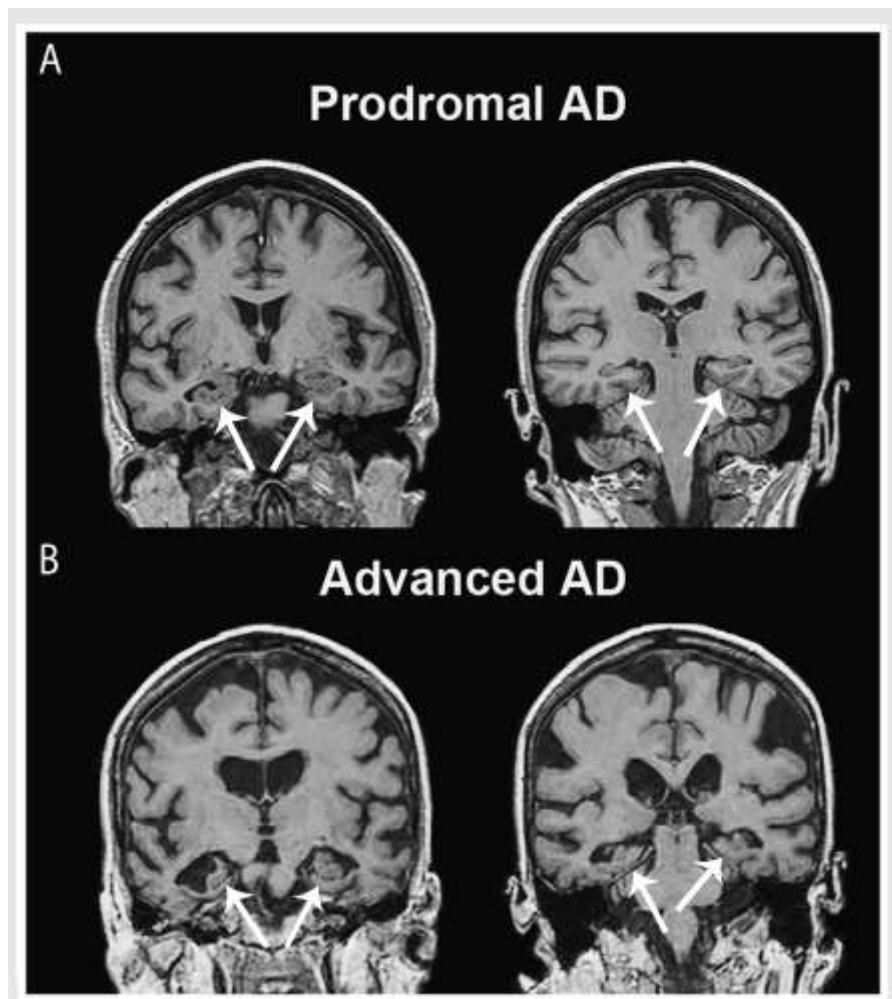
Coronal T1-weighted MRI slices with findings suggestive of Alzheimer disease (AD) pathology show mesial temporal atrophy (A, B, arrows) and, in the more advanced stages, global brain atrophy with pronounced ventricular enlargement.
